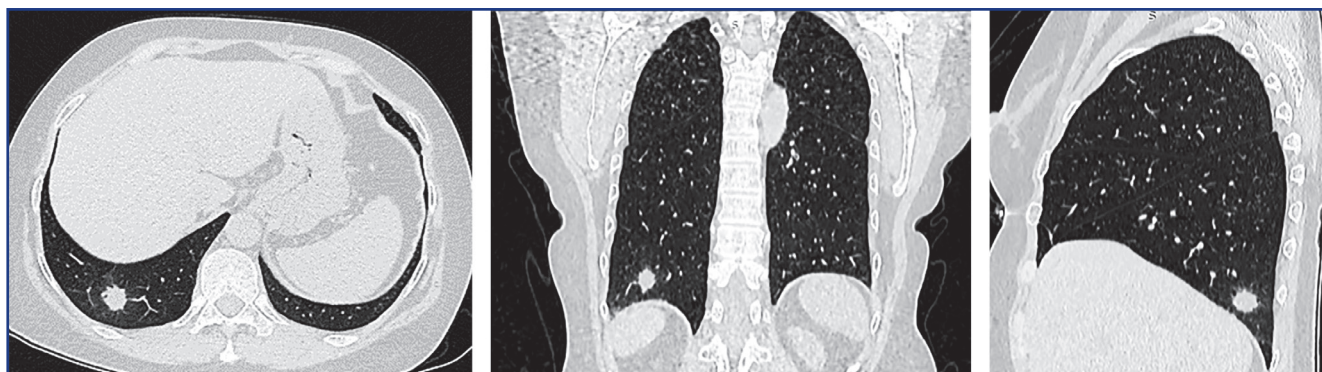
Thoracic computed tomography of patient Zh., 59 years old: Peripheral cancer of the lower (S10) lobe of the right lung
